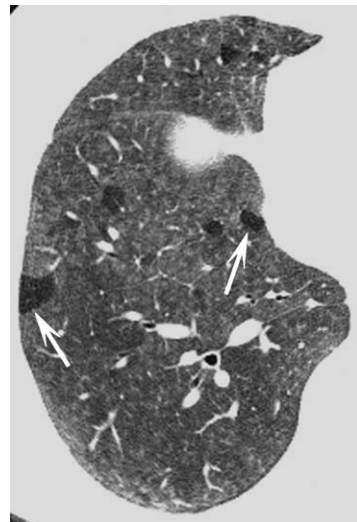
Inhomogeneous lung opacity: lobular low attenuation indicating presence of mosaic perfusion. Coned axial HRCT image in a patient with hypersensitivity pneumonitis shows areas of decreased attenuation in the shape and size of secondary lobules (*arrows*). This pattern of lobular low attenuation, in the presence of physiologic evidence for airflow obstruction or when extensive, suggests mosaic perfusion caused by an airway etiology, most commonly bronchiolitis.
